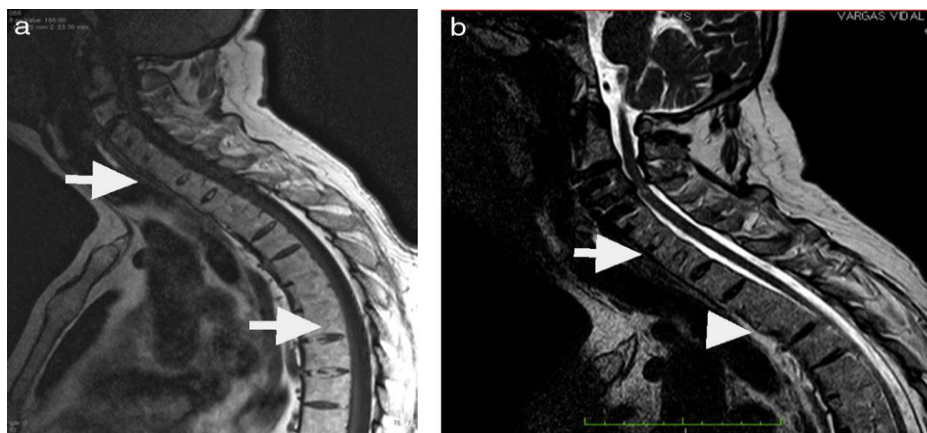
MRI showing signal ~ similar to bone marrow in disc spaces. One image weighted at T1 (a) and another at T2 (b) show bone marrow signal in vertebral discs (arrows)
